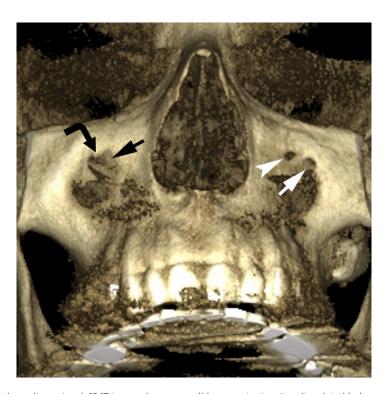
The preoperative three-dimensional CBCT image shows a small bony projection (i.e., lingula) (*black curved arrow*) above the wide right infraorbital foramen (*black arrow*) measured 4.62×3.11 mm. Left infraorbital foramen (*white arrow*) and accessory foramen (*white arrowhead*) measured 2.60×1.90 mm and 1.82×1.79 mm. Printed with permission and copyrights retained by I.I.F.
